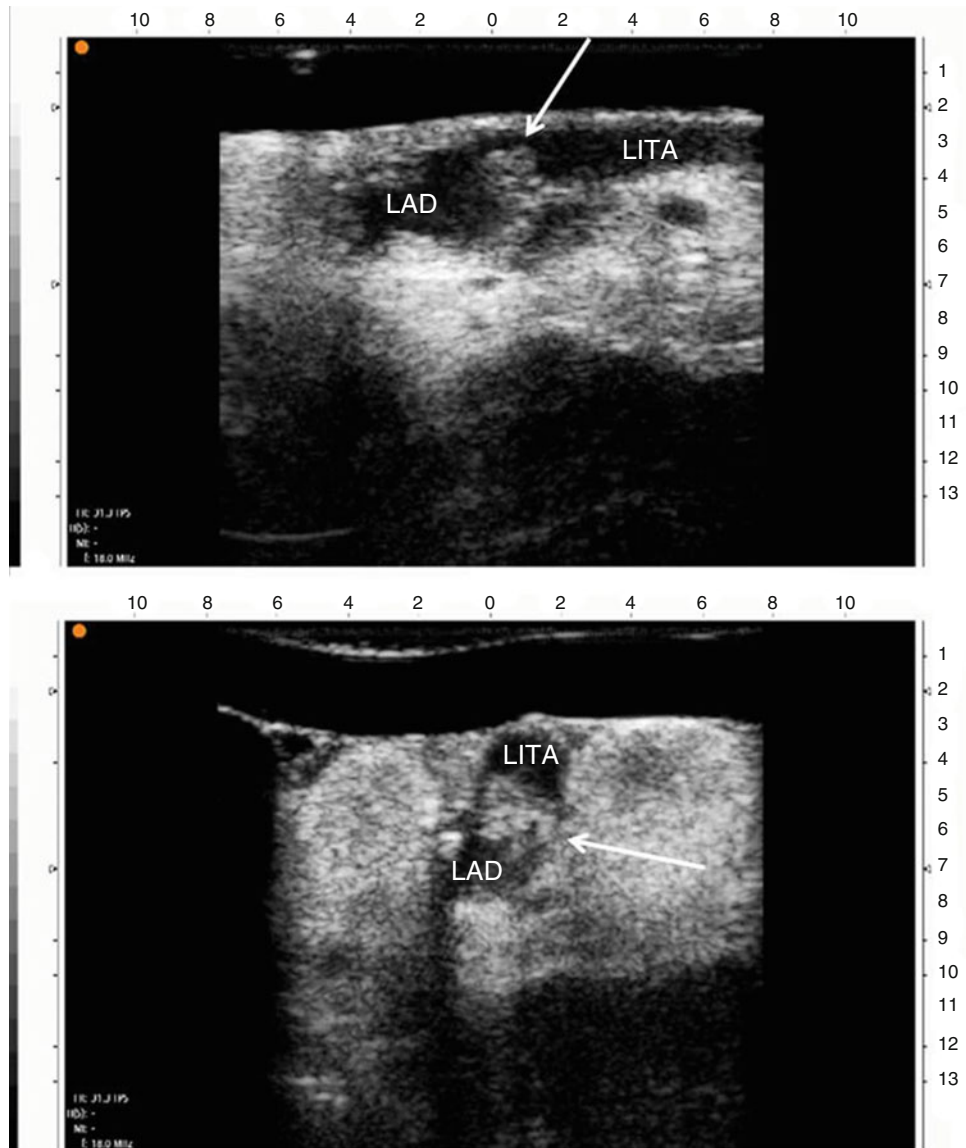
Epicardial ultrasound image of a patent right internal thoracic artery grafting (RITA) to left anterior descending artery (LAD): longitudinal image (*upper panel*) with corresponding transverse image (*lower panel*)
